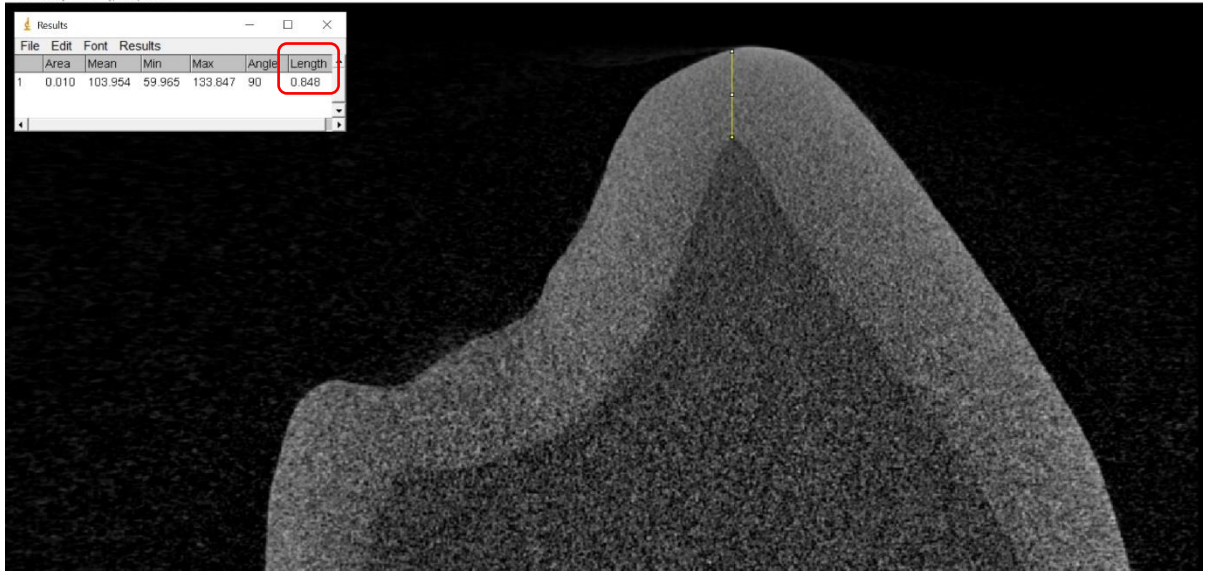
Example of measurement of BEWE 1 sample on μ -CT sagittal image.
